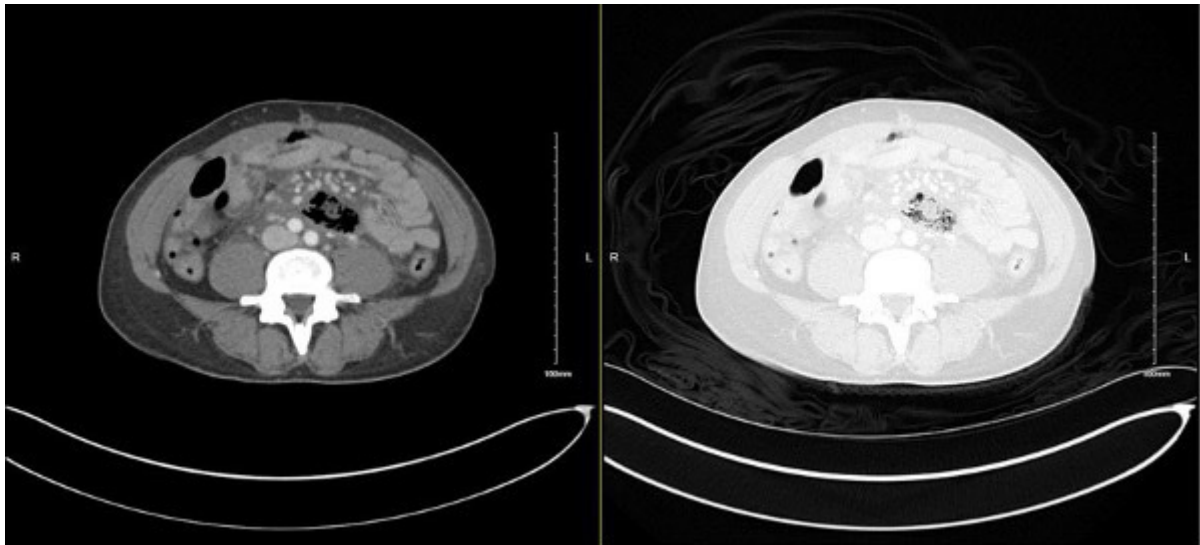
Computed tomography abdomen pelvis (CTAP) axial view of abdomen with intraperitoneal free air in relation to perforation of third duodenal portion.
